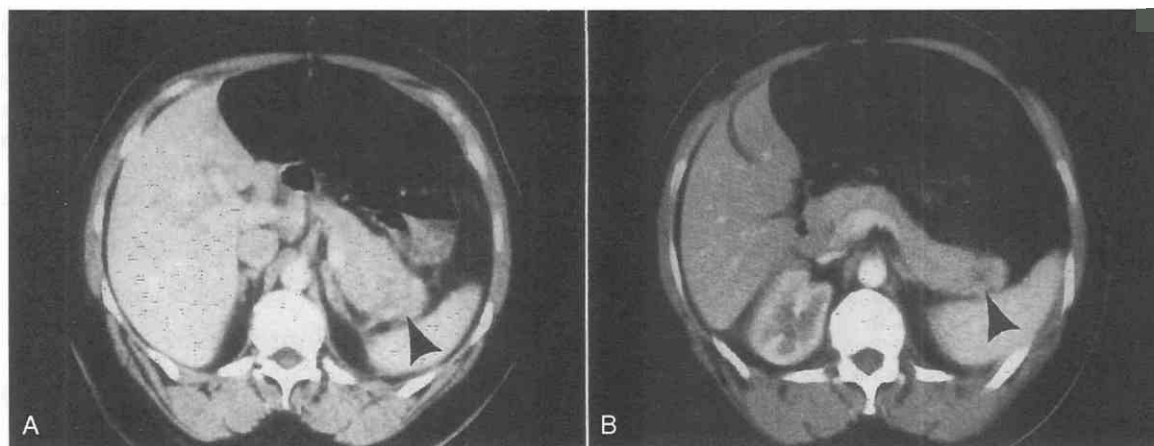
A, CT scan shows focal enlargement of the tail (arrowhead) secondary to pancreatitis. B, After resolution, the gland returned to normal size (arrowhead), but residual focus of fibrosis remains.
